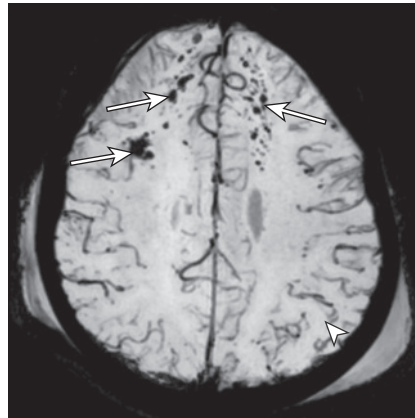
Magnetic Resonance Imaging. (A) Axial gradient-echo sequence showing multiple areas of low signal intensity (long white arrows) (B) Axial diffusion-weighted image demonstrates restricted diffusion in the corpus callosum due to DAI (short white arrow). White arrow head demonstrates normal vessels.
